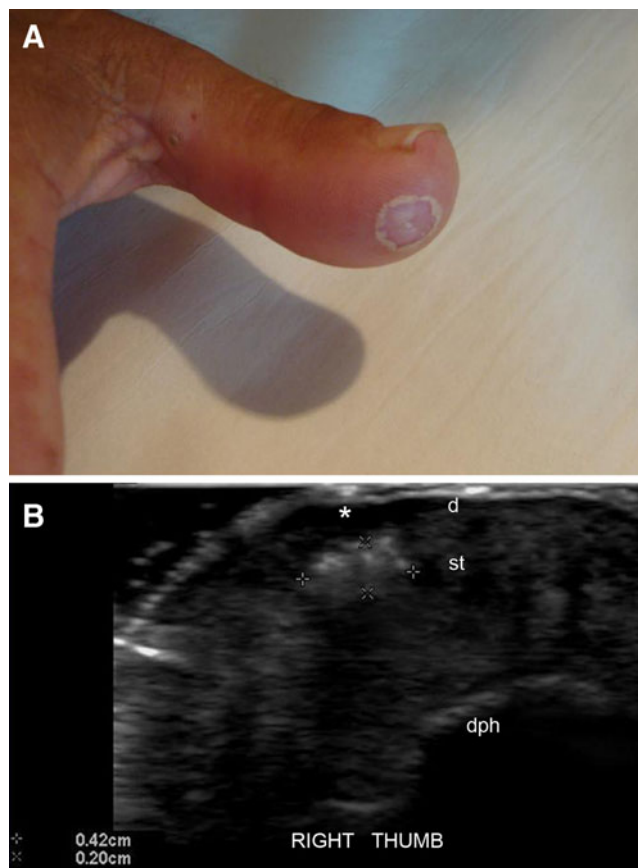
(A, B) Cutaneous calcinosis in scleroderma. A Skin lesion on the right thumb. B Ultrasound (transverse view) shows a 4.2 x 2.0-mm hyperechoic nodule in the subcutaneous tissue that corresponds with the calcium deposit. Decreased echogenicity of the lesional dermis (*asterisk*) is also detected. Abbreviations: *d* dermis, *st* subcutaneous tissue, *dph* distal phalanx
